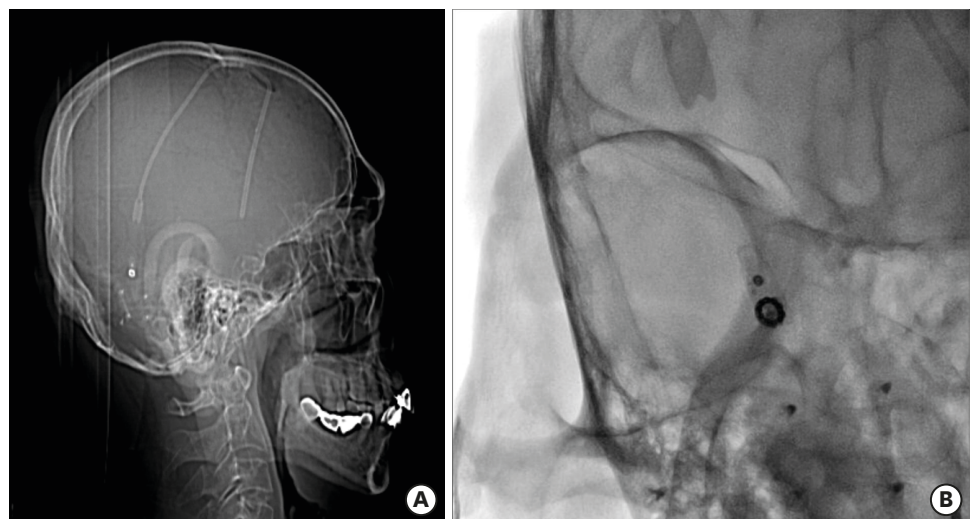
(A) Brain computed tomography scout film taken when the patient initially complained of progressive gait disturbance at the outpatient clinic. By retrospectively reviewing this image, we became aware that the distal catheter was missing and that it was already gone 5 months before admission. (B) One of the skull plain radiographs taken in between a period of 5 months from the initial symptom presentation to admission. It was a magnified image to confirm the shunt pressure setting which made it difficult to notice the absence of the distal catheter.
